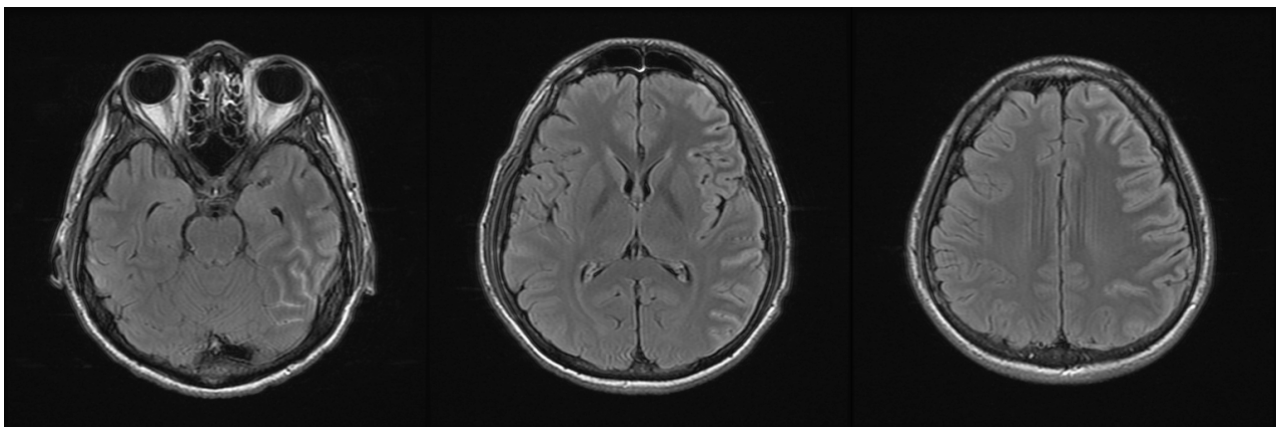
Postcontrast magnetic resonance imaging of the brain revealed prominent leptomeningeal enhancement along the left cerebral cortex.
